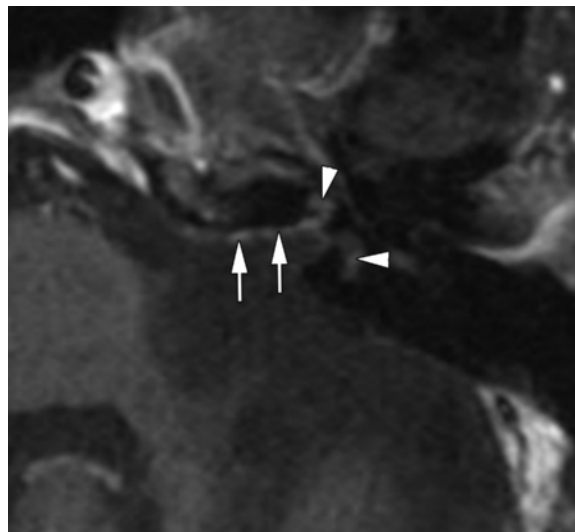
Diminished endolymphatic signal caused by a vestibular schwannoma. Axial 3D T2-weighted SPACE image obtained prior to resection shows a vestibular schwannoma that fills the right IAC. Endolymphatic signal intensity is diminished throughout the right cochlea (arrow) and vestibule (arrowhead) compared with the normal left side.
